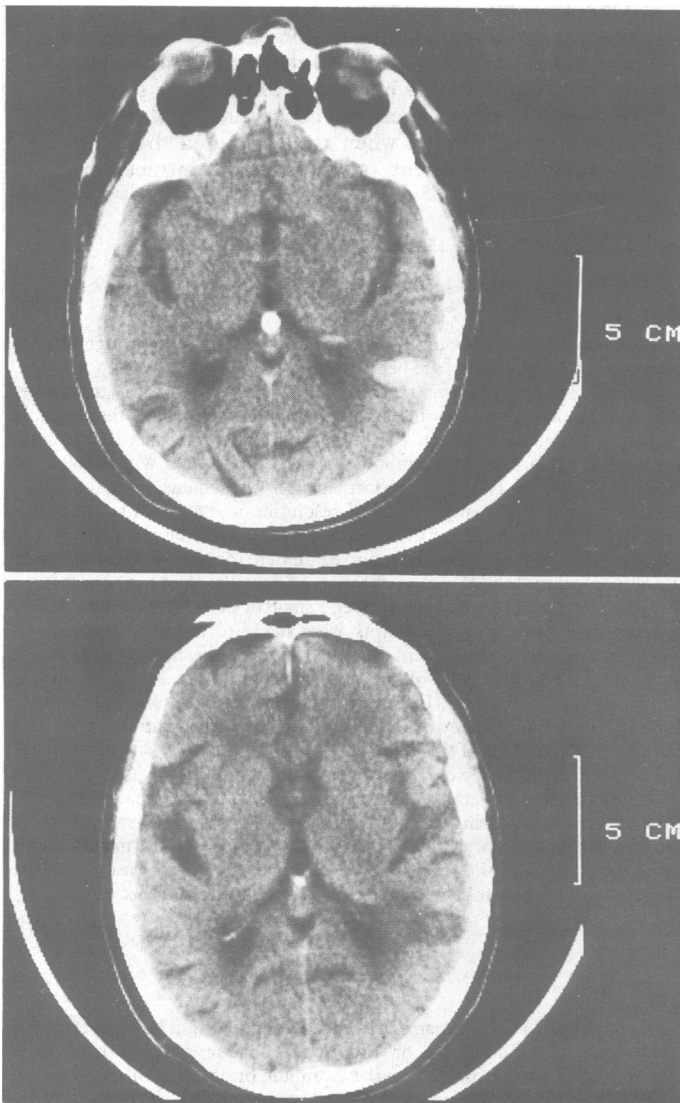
Case 3. Computed tomograms showing right parietal haemorrhage at seven days (top), which had resolved by 21 days, leaving a low density area (bottom). The late scan could have been interpreted as showing cerebral infarction in the distribution of a distal branch of the right middle cerebral artery.
